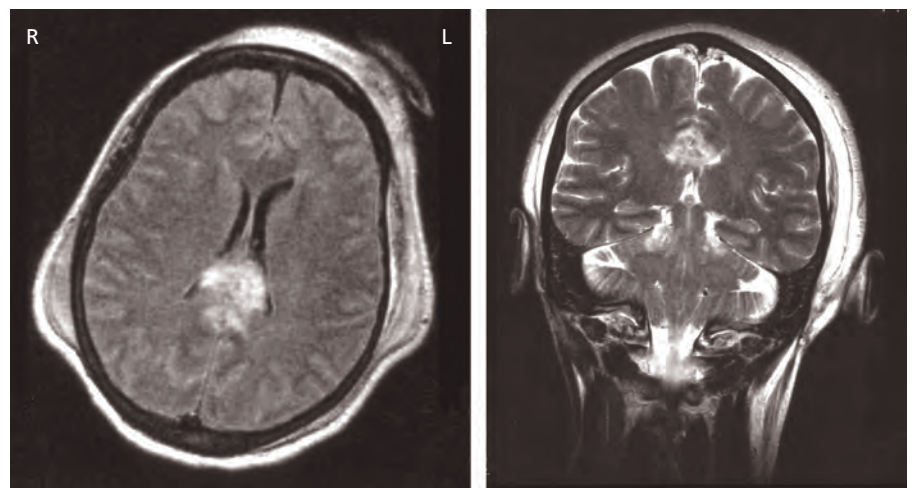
Diffuse axonal injury showing extensive haemorrhagic change in the region of the splenium (MRI T1-weighted axial and coronal).
